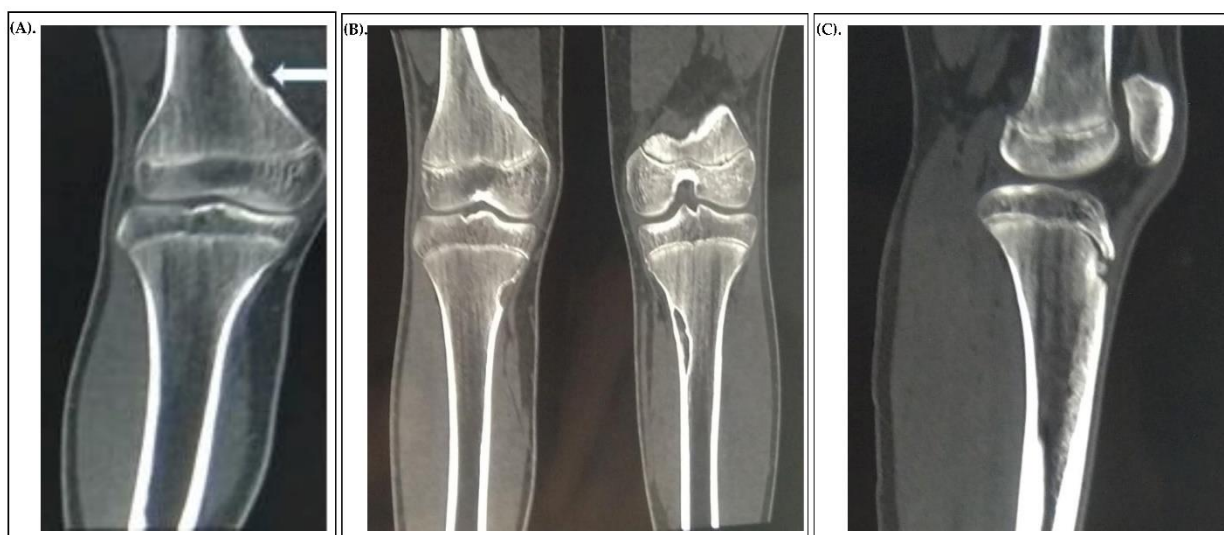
Radiological findings of the patients. (A) Patient P, 15 years old, CT scan of the lower leg showing a fibrous cortical defect of the distal metaphysis of the left femur. (B) Patient P, 15 years old, CT scan of the lower leg showing a fibrous cortical defect of the distal metaphysis of the left femur. (C) Patient P, 15 years old, CT scan of the lower leg showing osteoporosis and fragmentation of the apophysis of the left tibia (Osgood-Schlatter disease).
